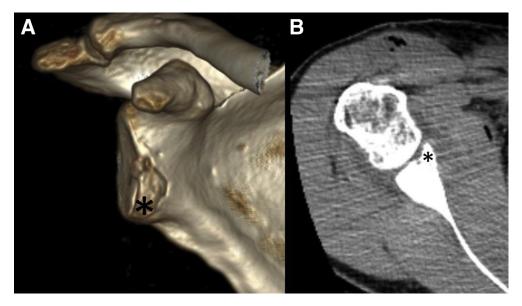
Postoperative imaging of the right shoulder presented in the case. (A) 3-Dimensional computed tomography (CT), anterior view. (B) 2-Dimensional CT, transverse scan. Fracture fragment (*) is reduced anatomically on the glenoid.
